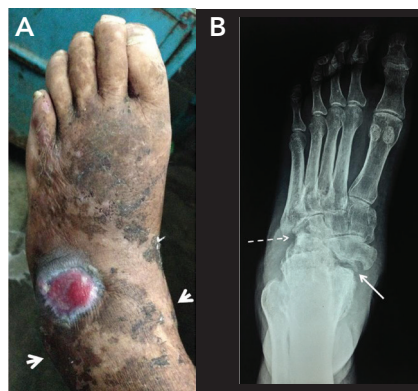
Case 3. *A*) Widening of the ankle mortise (between arrowheads) and midfoot with partially healed dorsal ulcer. *B*) X-ray showing involvement of talo-navicular (solid arrow) and calcaneo-cuboid joints (dashed arrow), suggestive of pattern III CF.
